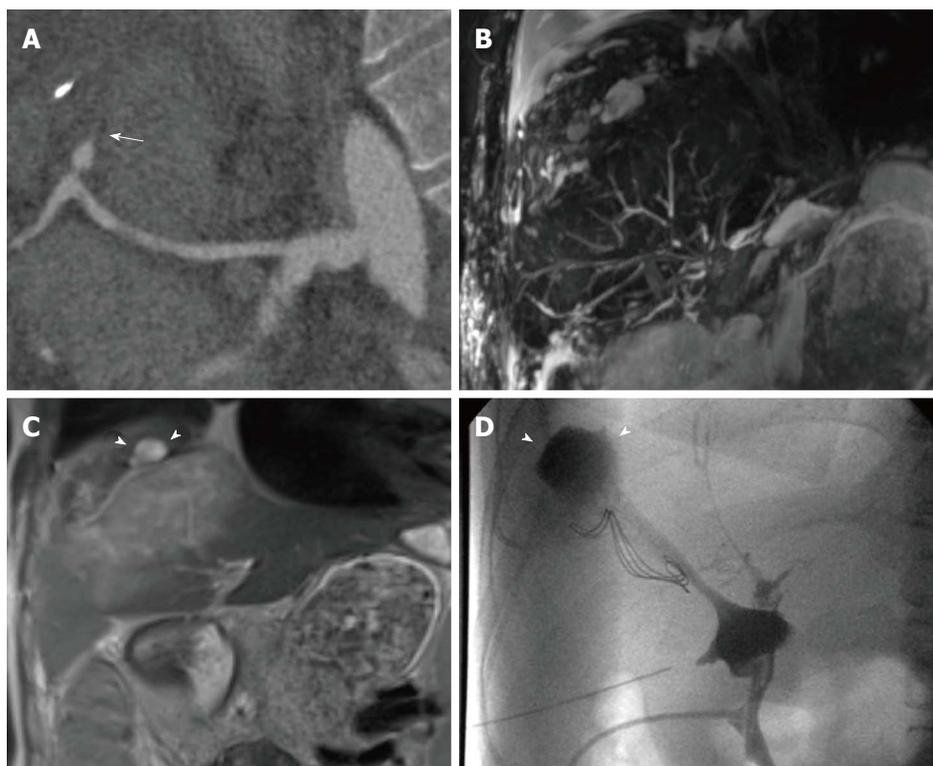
Multiple findings in a 28-year-old female patient transplanted for primary sclerosing cholangitis. Because of the hepatic artery thrombosis shown on curved-reformatted CT image (arrow in A), the biliary tree appears as fragmented and anatomically ill-defined on a panoramic maximum intensity projection view (B). Coronal T2-weighted HASTE image (C) shows extensive, hyperintense ischemic damage of liver parenchyma, together with intrahepatic fluid collections (arrowheads) confirmed to be the effect of bile leakage on T-tube cholangiography (arrowheads in D).
